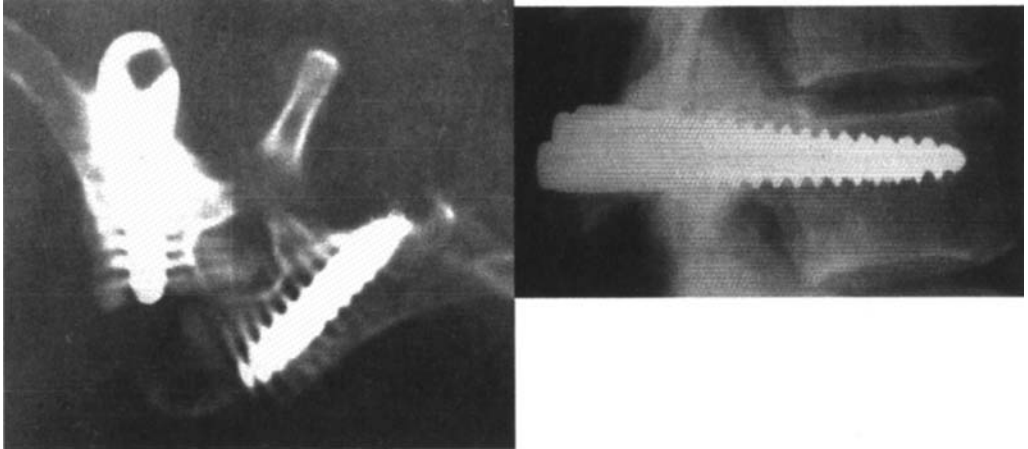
Computer (left) tomograph of an extrapedicular screw (6mm) at T4. Note the distance of the screw to the spinal canal. (Right) Lateral x-ray demonstrating extrapedicular screw placement at T4.
